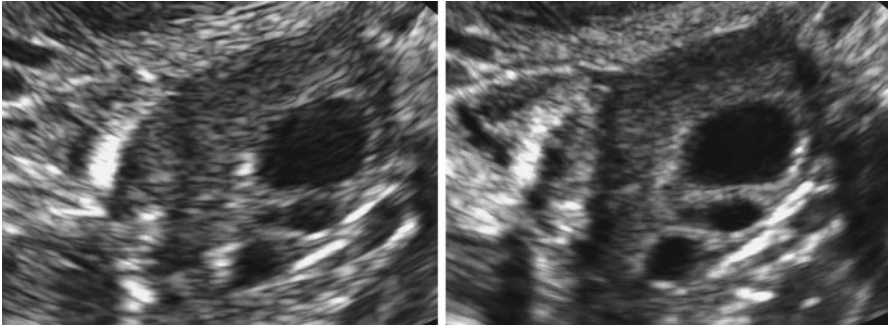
Effect of the harmonics on image quality when using 2D ultrasound: same ovary without (*left*) and with harmonics (*right*)
